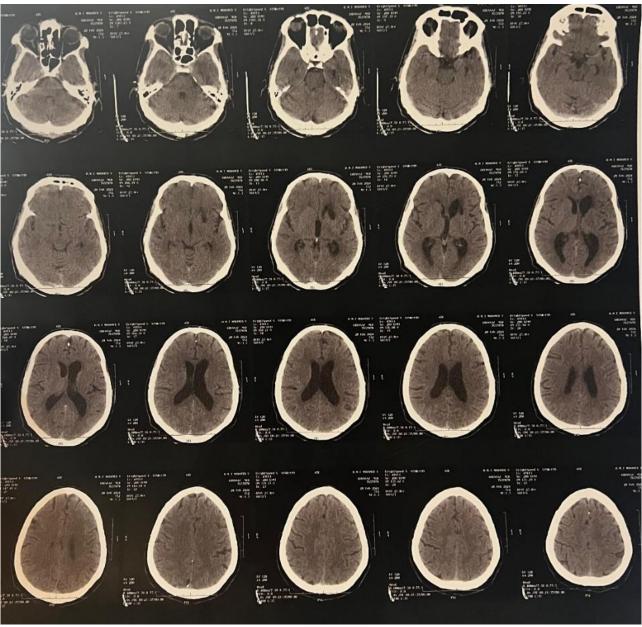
Cerebral CT scan showing ischemic territories
